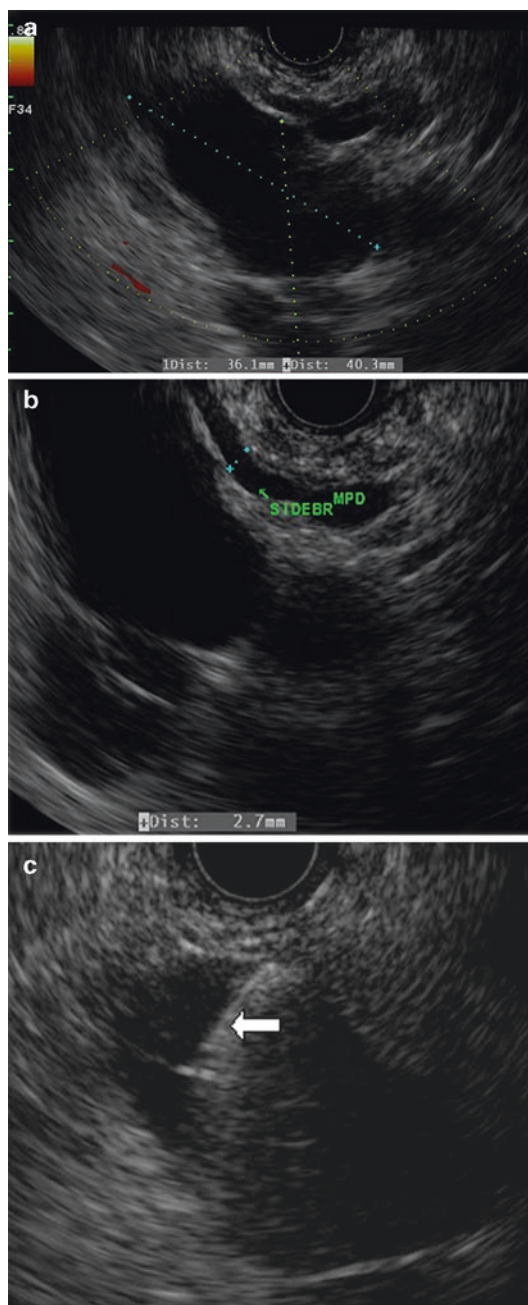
Linear EUS of a slowly enlarging 3–4 cm Doppler-negative anechoic (cystic) lesion in the head of the pancreas in a middle-aged man without a history of pancreatitis. (a) A thin-walled cyst is seen with a dilated side branch (*SIDEBR*) from the main pancreatic duct (*MPD*) filling the cyst. (b) The lobular/tubular cyst morphology is consistent with a cluster of dilated side branches. (c) FNA with a 19 G needle (*arrow*) removed thick mucin consistent with a side branch variant IPMN. An intracystic brushing was obtained through the needle, but both fluid and brushing were acellular
